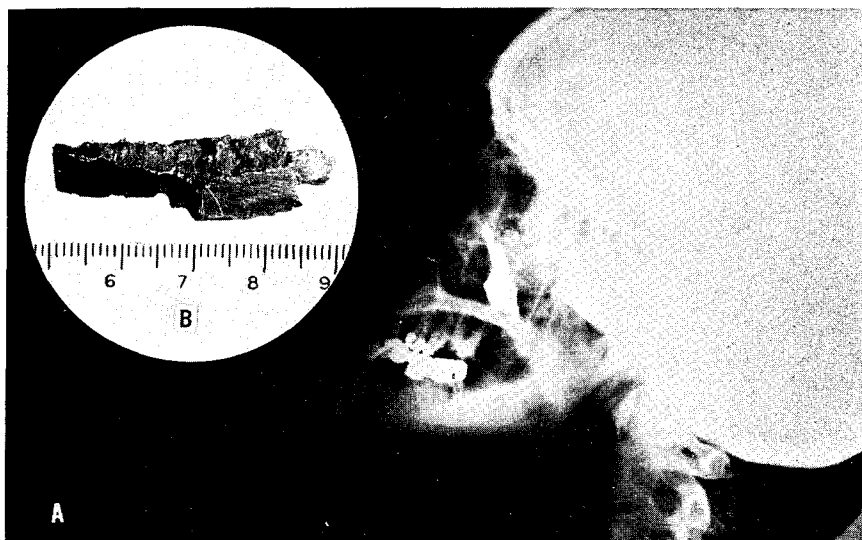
Roentgenogram of skull showing artillery shell fragment lodged in sinus cavity. A soldier, standing in the company area, was hit by a Japanese 75 mm. artillery shell which exploded at a distance of 100 yards. A fragment of the shell penetrated the outer wall of the maxillary sinus and lodged in the sinus cavity. This is a good example of the relative protection afforded by bony structures to low-velocity fragments, even of large size. A. X-ray of skull. B. Recovered fragment.
